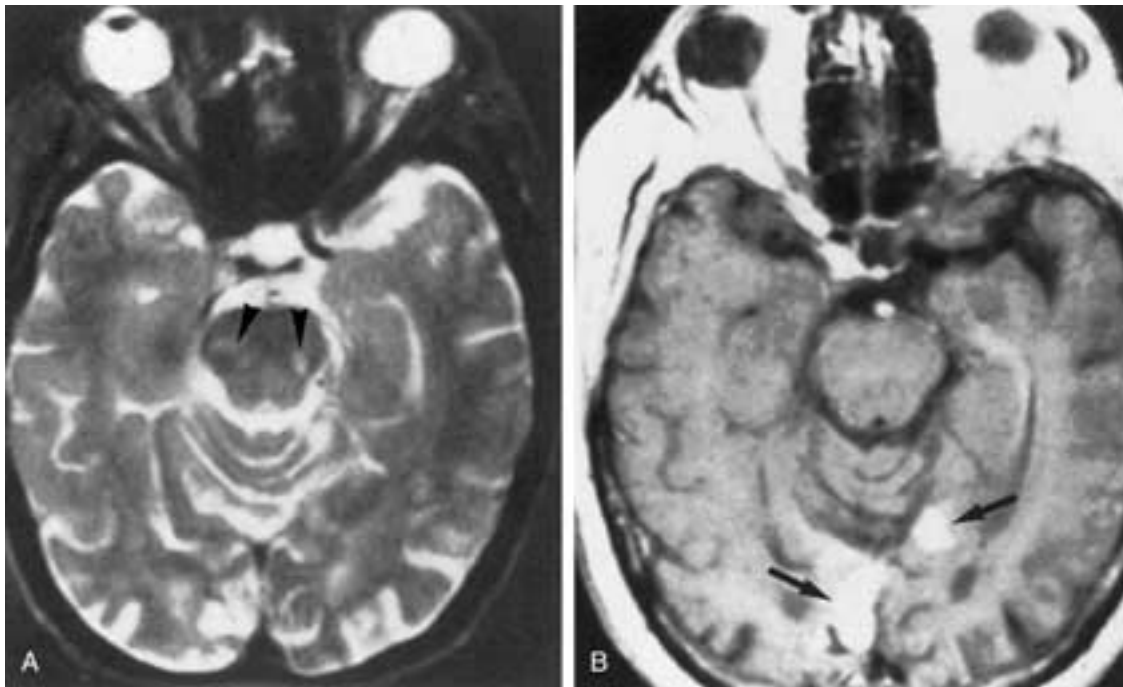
Multiple infarcts. A, Axial T2-weighted image shows several high-intensity foci in the upper pons (*arrowheads*) that are consistent with small infarcts. B, Axial T1-weighted image after injection of contrast medium shows enhancement of the right occipital lobe and left medial temporal lobe infarcts (*arrows*) not seen on the T2-weighted image.
